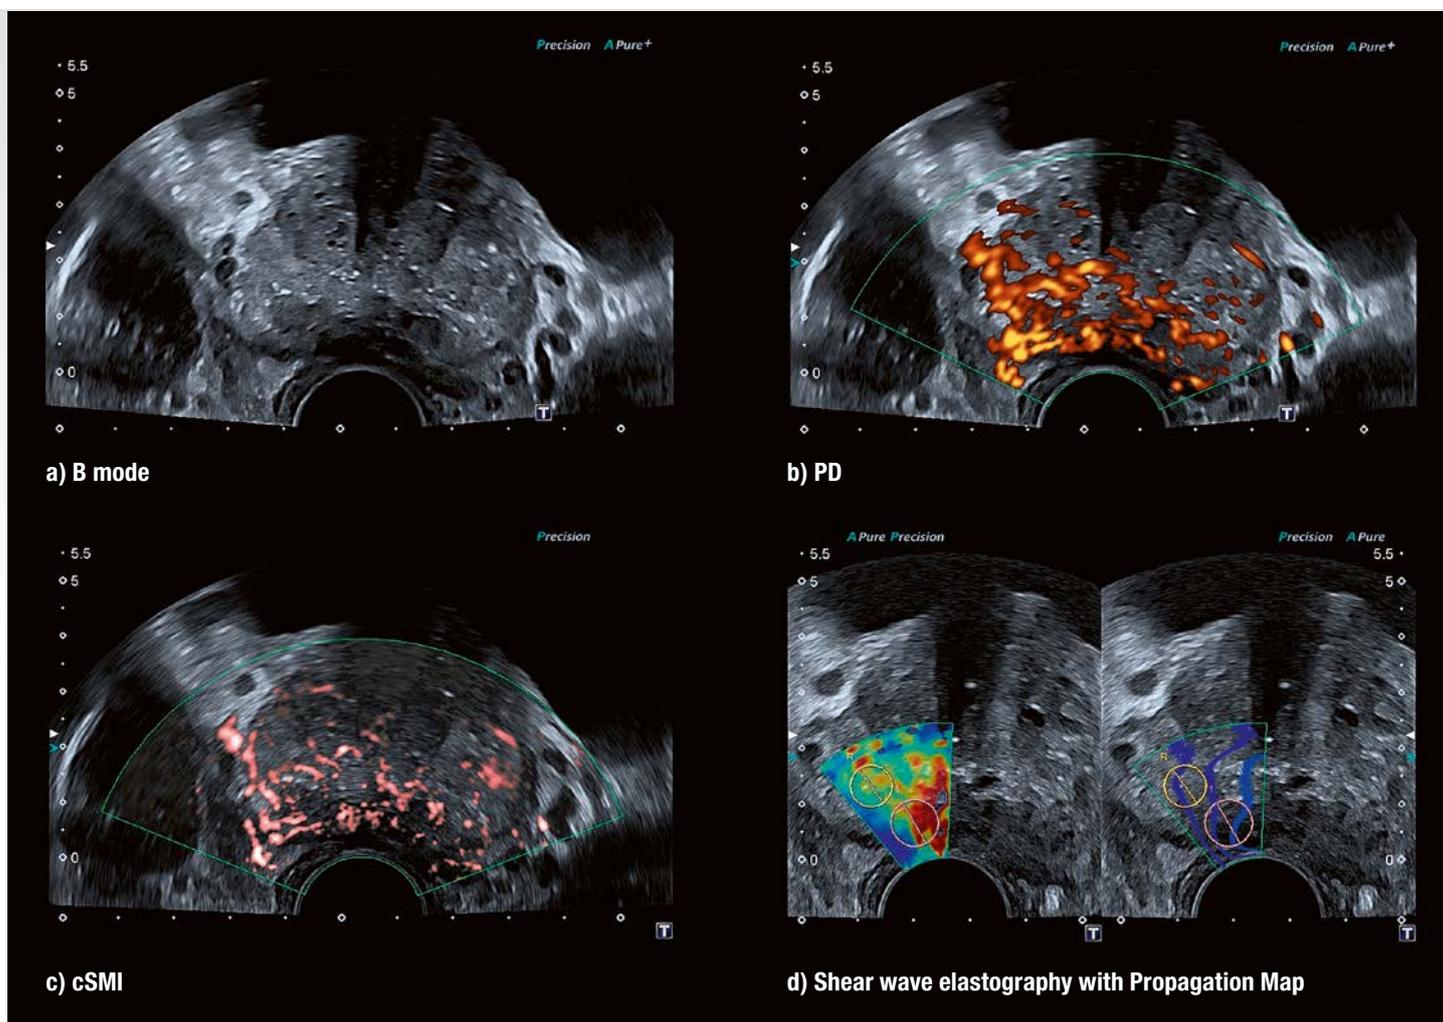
(a–d): US assessment of the prostate: An area of lower echogenicity in B-mode (a) showed during Doppler evaluation with PD (a) and especially with SMI (b) a high peripheral vascularity. An elasticity value of 90 kPa within the area of interest was recorded by shear wave elastography (c).
